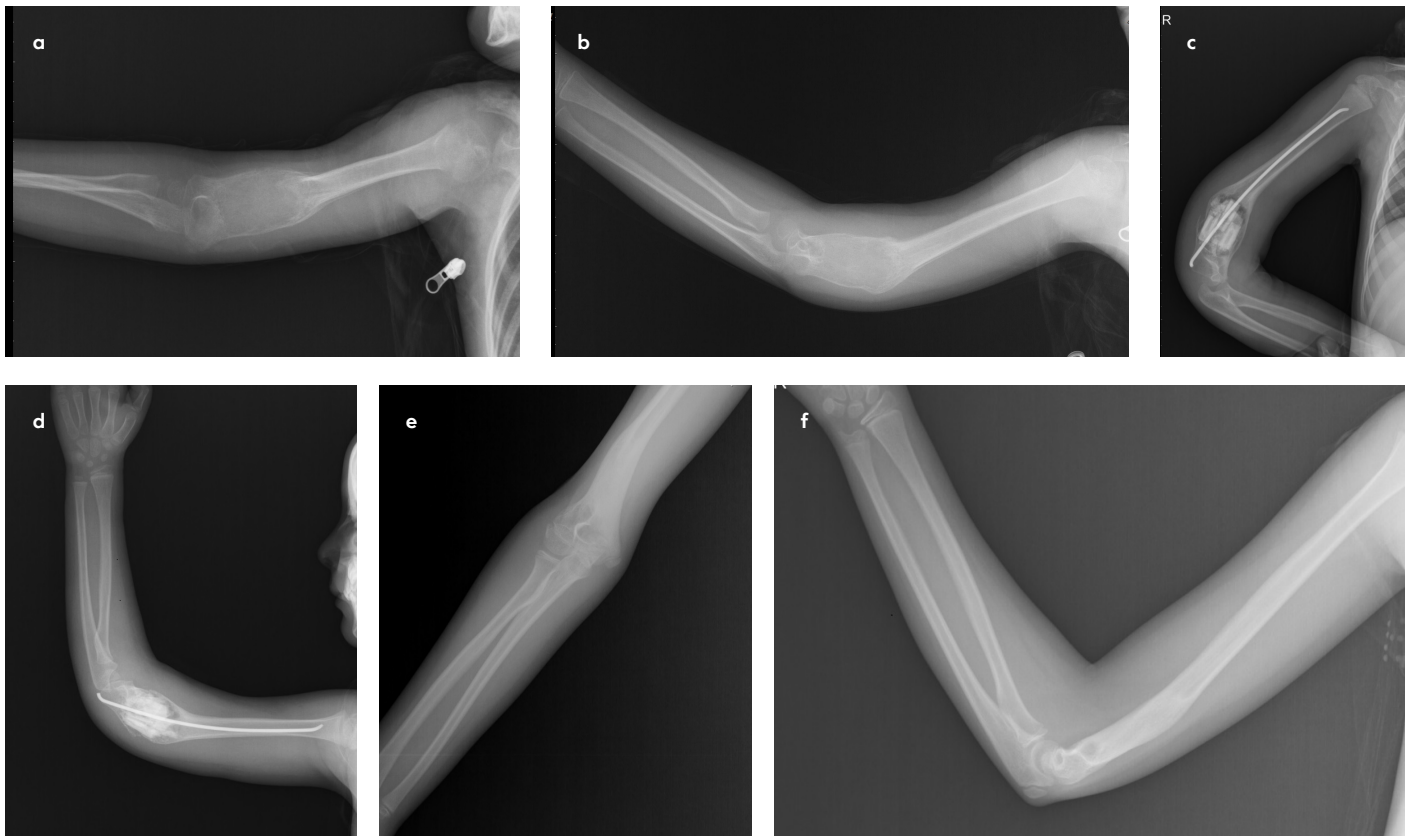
a-f. A 9-year-old girl with a right distal humeral fracture resulting from a simple fall. (a, b) Preoperative X-rays; (c, d) Postoperative X-rays; (e, f) X-rays 56 months after surgery
